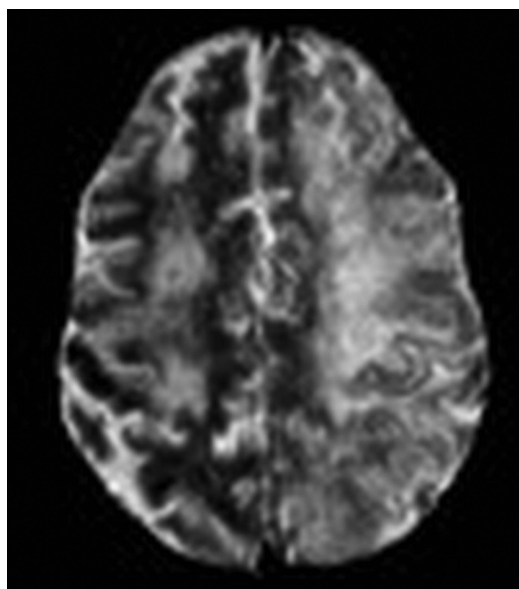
MRI fluid-attenuated inversion recovery sequence showing changes consistent with acute stroke (see arrows).
